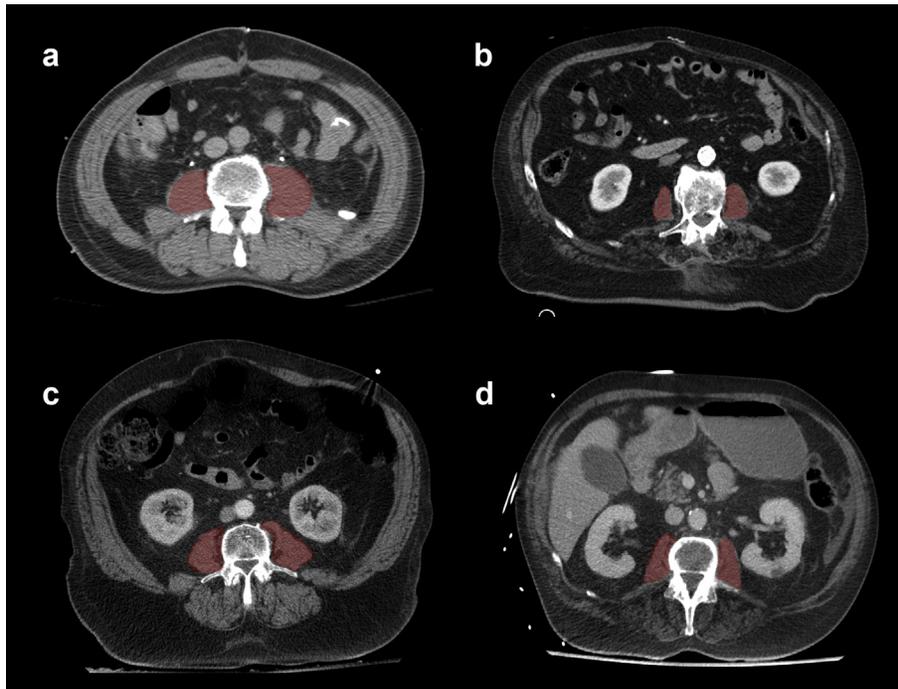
Psoas sarcopenia and vertebral osteopenia in a single CT image at L3 level. A single image from abdomino-pelvic CT can be used to assess sarcopenia and osteopenia at the L3 level by assessing for psoas muscle cross-sectional area (CSA) as a marker of sarcopenia and vertebral bone density as a marker of osteopenia. (a) Normal psoas CSA and bone density, (b) sarcopenia with normal bone density, (c) normal psoas CSA with osteopenia, and (d) sarcopenia and osteopenia. The psoas muscle is coloured in red.
